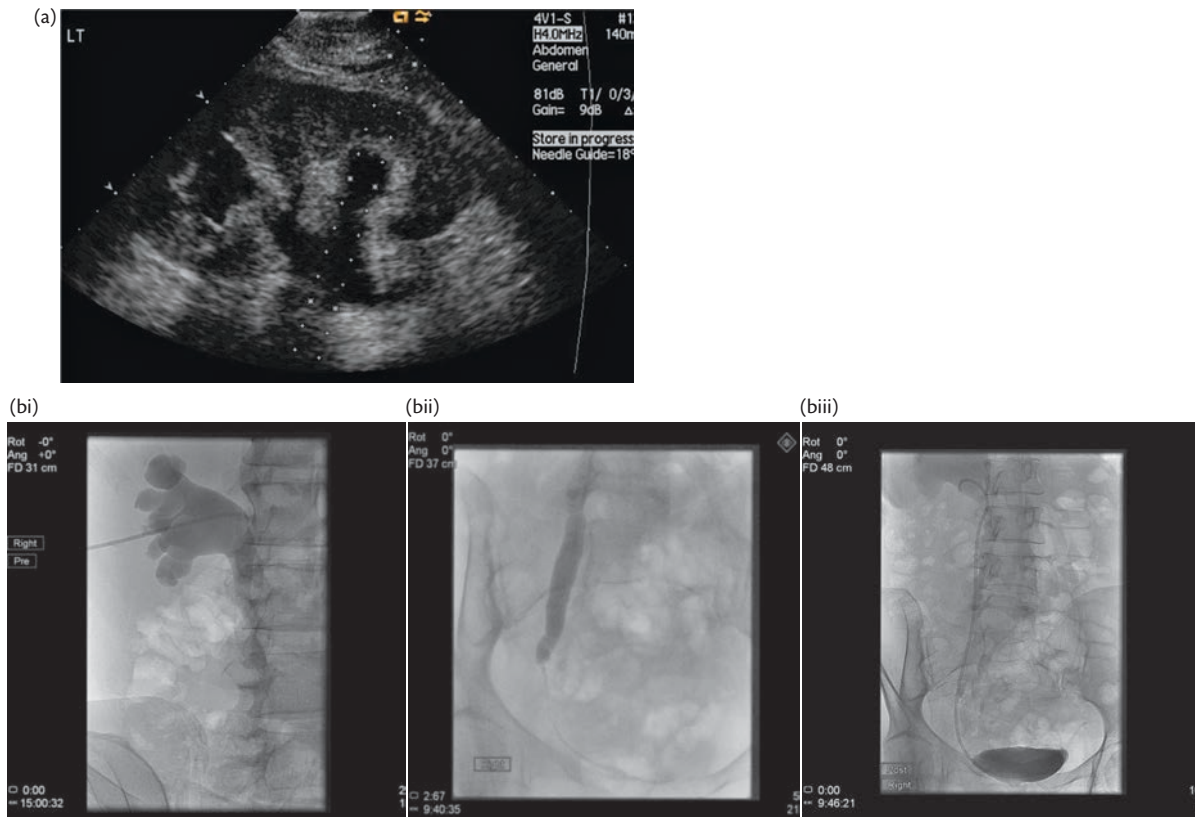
(a) Hydronephrotic kidney. The dilated pelvicalyceal system shows up as an echo-free branching structure within the renal sinus fat. Note that the guidelines for an ultrasound guided nephrostomy are aimed at the lower pole calyx. (b) Sequence of three fluoroscopic images. The first shows the dilated pelvicalyceal system is opacified by contrast medium instilled via a nephrostomy catheter. The second shows a distal extrinsic ureteric stricture that has produced the hydronephrosis. The third shows a ureteric stent in place across the stricture.
